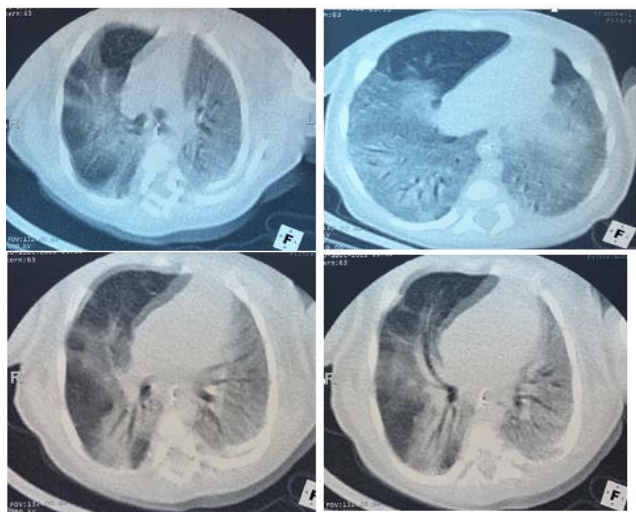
Chest CT (repeated at 5 days) showed of admission showed no improvement and accentuation on lung lesions.
